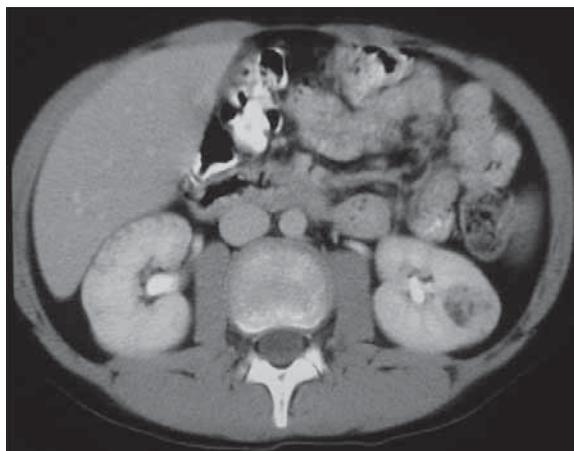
Abdominal CT with contrast enhancement (2003) in the same patient – a 2 cm tumor (angiomyolipoma) in the inferior pole of the left kidney.
